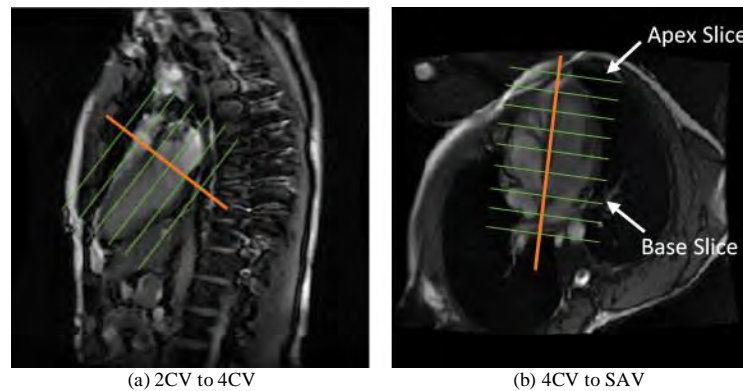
Positioning of MRI slices to obtain different MRI views
